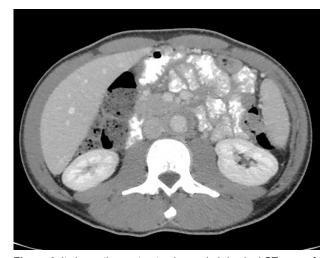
It shows the contrast enhanced abdominal CT scan of a patient demonstrating retroperitoneal fibrosis.
